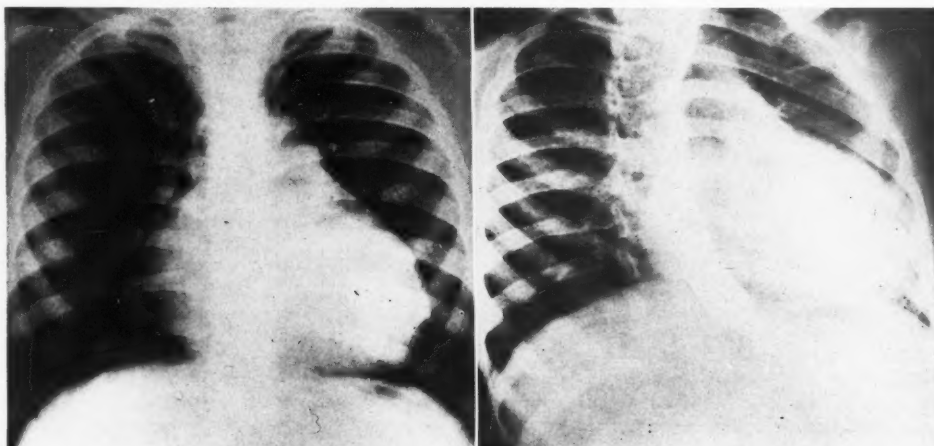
Case 1. Roentgenograms in frontal (left) and right anterior oblique (right) projections show cardiac enlargement, in particular of the right atrium and right ventricle, and absence of poststenotic dilatation of main pulmonary artery. Peripheral lung fields hypovascular. (Reprinted with permission from *Pediatrics* 19: 1144, 1957.)
